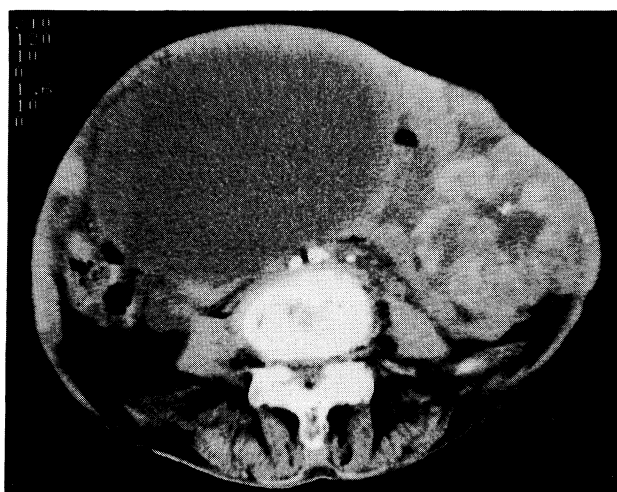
Axial CT revealed a giant inhomogenous mass in the pelvic space.
